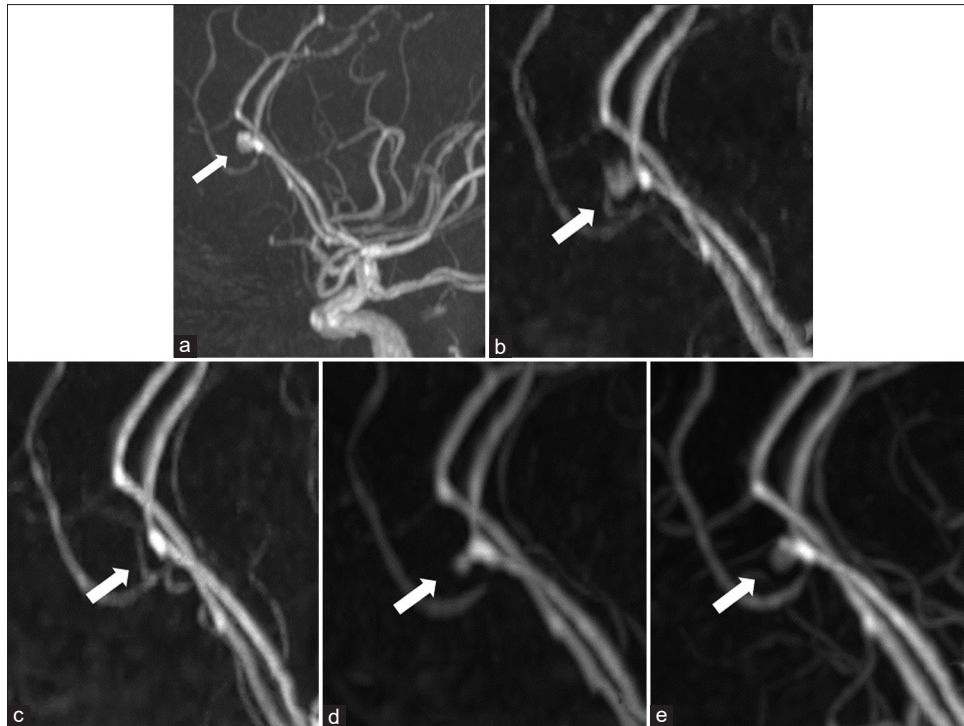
(a) Magnetic resonance imaging at first examination showing a small unruptured aneurysm (arrow) arising from the distal anterior cerebral artery. (b) Magnetic resonance imaging performed 4 years after the initial diagnosis showing a slight reduction in aneurysm size. (c) Magnetic resonance imaging performed 5 years after the initial diagnosis showing complete disappearance of the aneurysm. (d) Magnetic resonance imaging performed 2 years after disappearance showing spontaneous recanalization of the aneurysm. (e) Magnetic resonance imaging performed 1 year after recanalization showing a slight enlargement of the aneurysm
